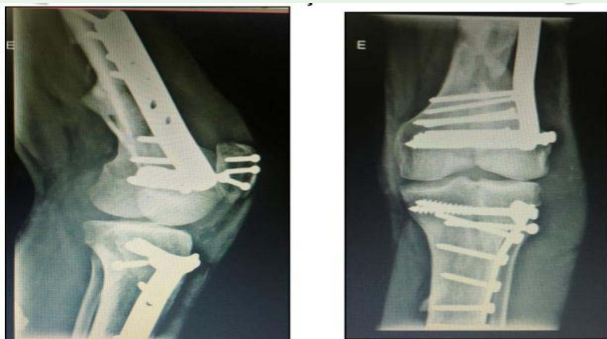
Radiographic bone consolidation with four months.
